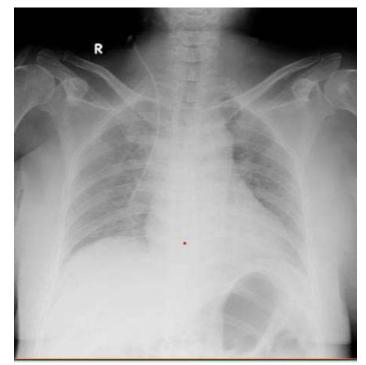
Chest X-ray Examination of the patient's. The impression of the distalend of the CVC is in the projection of the inferior vena cava
